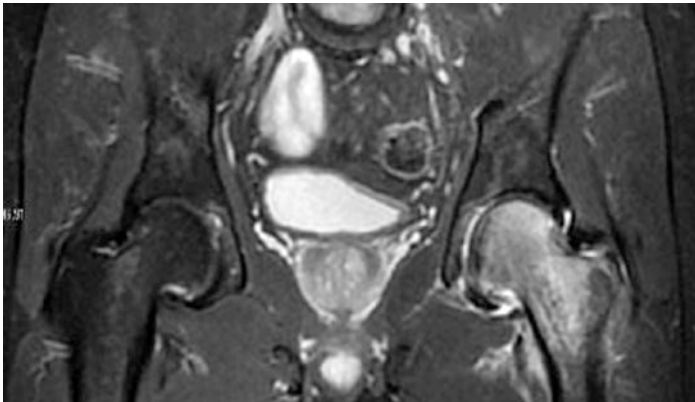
MRI view of bilateral hips. (Courtesy of Wikimedia Commons)
